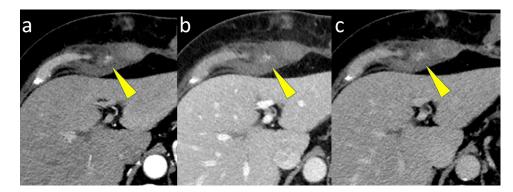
Axial images of computed tomography (CT) angiography obtained in the arterial (A), venous (B), and late (C) phases show active bleeding (yellow arrowhead) in superior region of hematoma.
